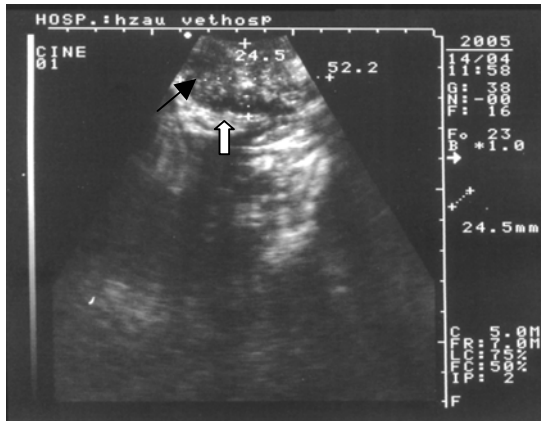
Ultrasonography of ovaritis. Right ovarian ultrasonography obtained with 7.0 MHz intrarectal transducer. A 52.2×24.5 mm size ovary filled with much hyper-echo spots and few little follicles (little black arrow) and no dominant follicle and luteum appeared. The ovarian edge connected with circumjacent tissues was untidy and hyper-echoic (white arrow)
